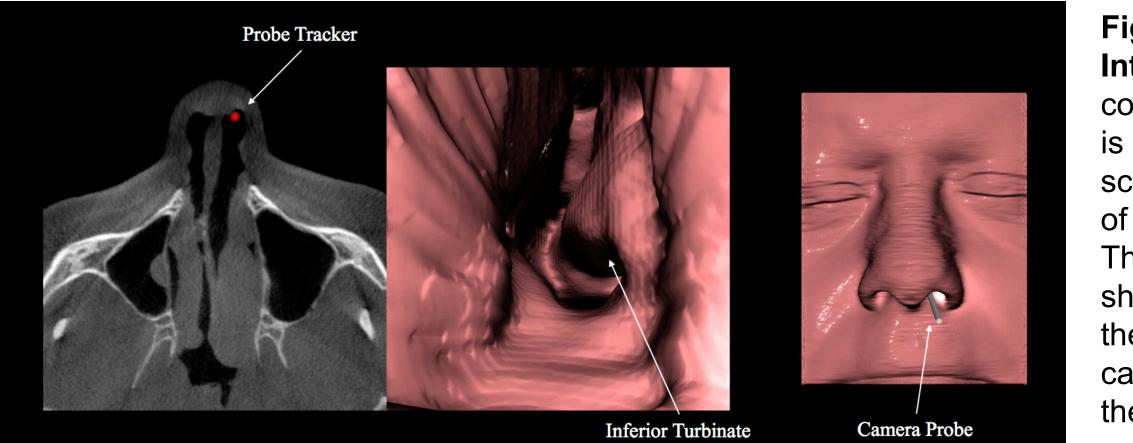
Unity* VR Interface. A user controllable probe is mapped to a scrolling axial view of the raw CT scan. The central display shows the output of the endoscopic camera, revealing the patient's anatomy.
